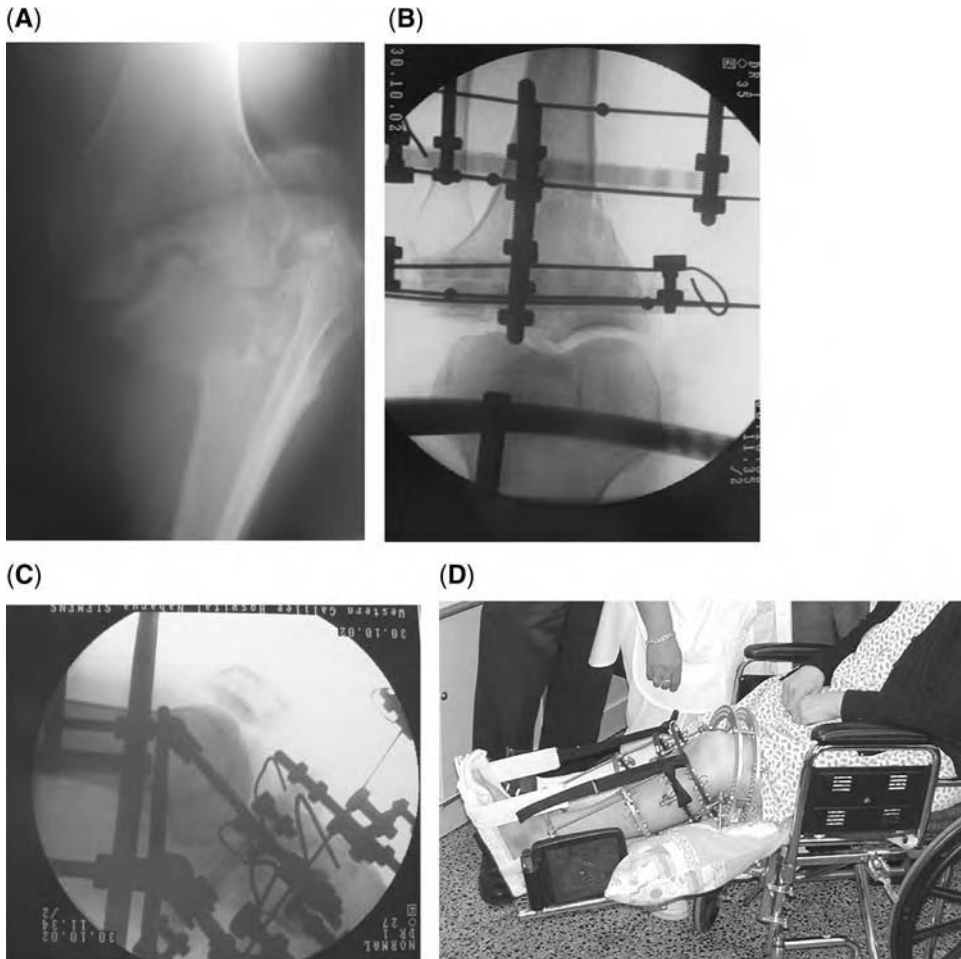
(A) X-ray of severe comminuted fracture dislocation of knee. (B) and (C) Postoperative A-P and lateral X-rays after reduction and ilizarov external fixation of previously shown fracture. (D) Clinical picture of the above patient. The ilizarov frame is extended to the proximal femur with use of knee hinges.
